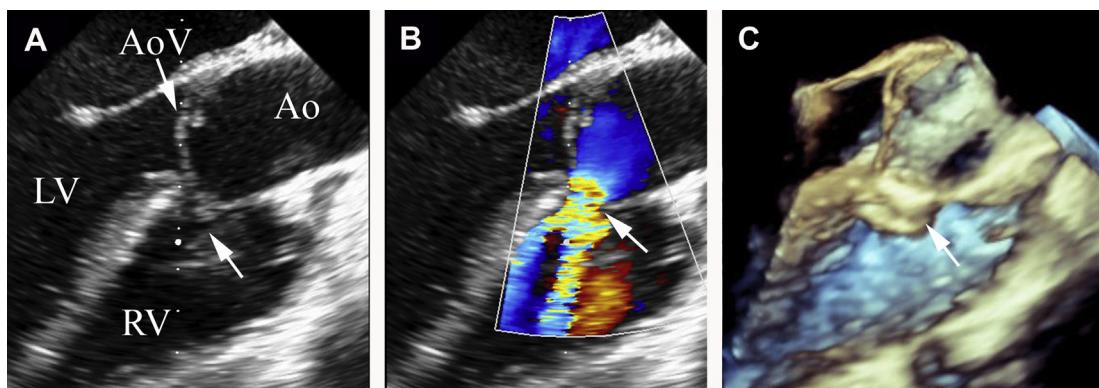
(A) Transesophageal 2-dimensional echocardiography long axis view demonstrating a communication between the aorta (Ao) and the right ventricle (RV) (white arrow) above the aortic valve (AoV) via a prolapsing aortic root sinus. (B) Color Doppler image demonstrating flow from the Ao to the RV via the ruptured right coronary sinus. (C) Three-dimensional transesophageal echocardiography after device closure of the ruptured sinus of Valsalva with an Amplatzer muscular VSD device (white arrow).
